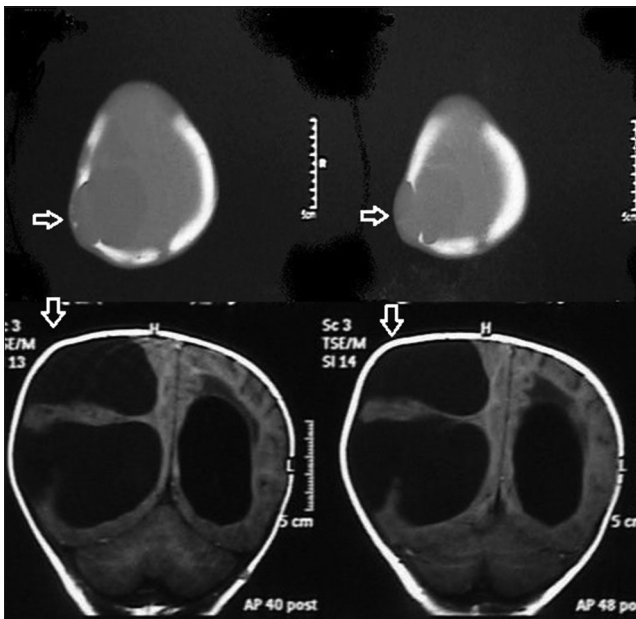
Bone window axial CT images and coronal section of MRI show a bone defect located in the right posterior parietal region with skin bulging
